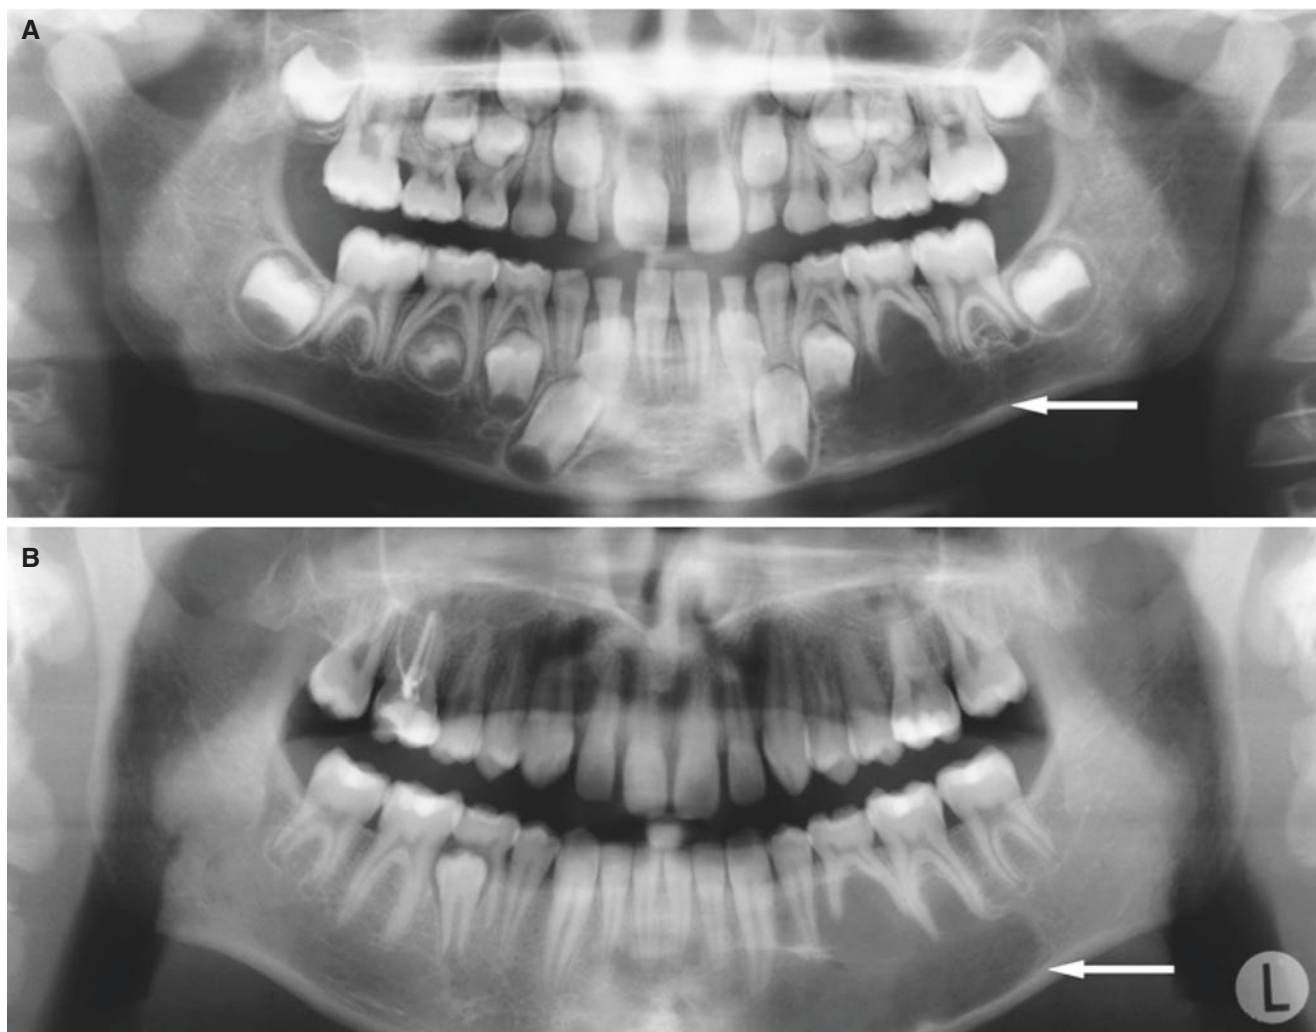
Simple bone cyst, mandible; 8-year-old male at baseline with incidental finding at routine dental radiography and followed for 8 years. (A) Panoramic view shows poorly defined radiolucency with no sclerotic border (*arrow*). At 6-year follow-up, after two surgical interventions, (B) panoramic view shows enlarged radiolucency (*arrow*). (C) Axial CT image shows expanded, thinned, and intact cortical bone (*arrow*). (D) Axial T2-weighted MRI shows homogeneous high signal
